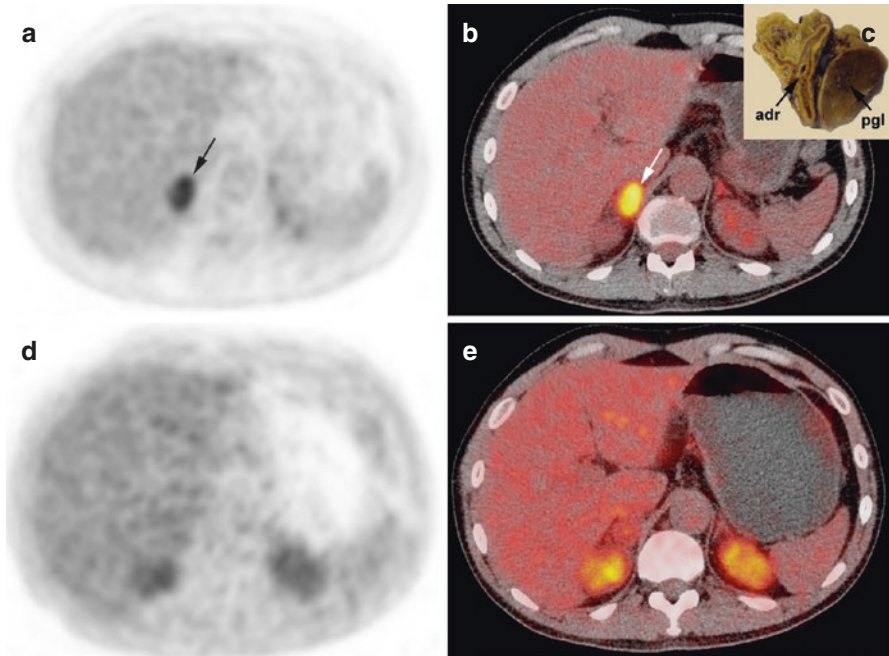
Para-adrenal PGL in a *SDHD* patient. Axial ^{18}F -FDG PET (a) and PET/CT (b) and ^{18}F -FDOPA PET (d) and PET/CT (e). ^{18}F -FDG PET was positive, while ^{18}F -FDOPA PET was considered as falsely negative. Gross pathology showed that the tumor was developed from para-adrenal paraganglia (*adr* adrenal, *pgl* paraganglioma) (c)
